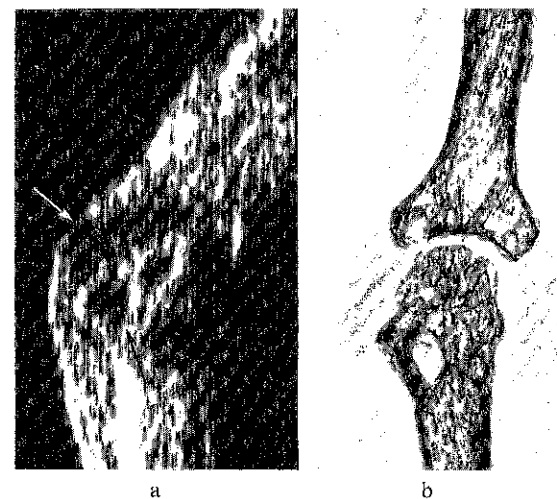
Longitudinal scan of the second metacarpo-phalangeal joint (a). The soft tissue swelling corresponds to a hypoechoic widening of the articular space (→). A couple of osseous cavities (geodes) can be recognized within the metacarpal head (↔) corresponding to the findings at radiography (b).
